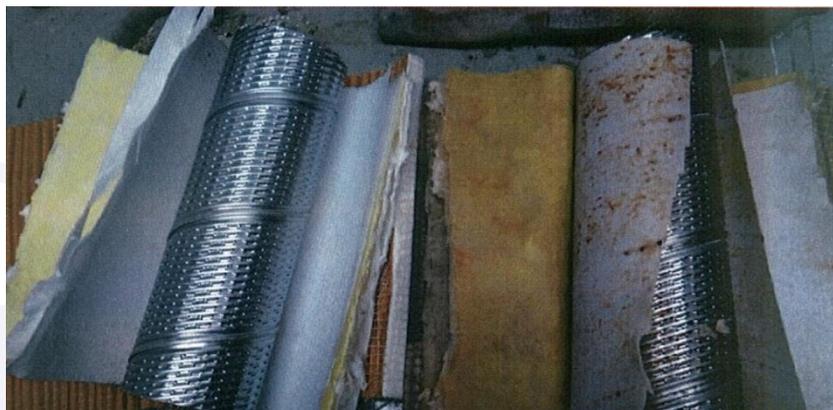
New filter (left) without contamination and filter removed from CTA (right) with contamination.
